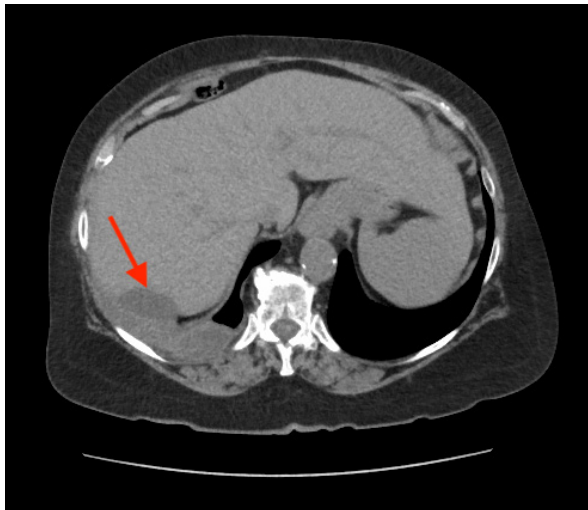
Axial Computed Tomography Without Contrast Taken Upon Admission Showing Enlarging Right-Sided Posterior Liver Mass Pleural Effusion (blue arrow)
